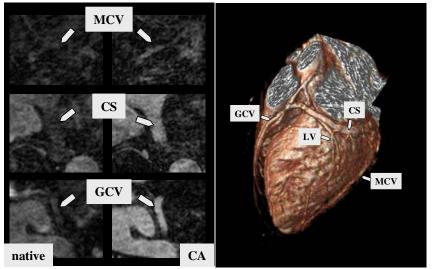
Comparison of native MRI and contrast-agent enhanced MRI (CA) for the mid cardiac vein (MCV), the coronary sinus (CS), and the great cardiac vein (GCV) (left); three-dimensional rendering of the coronary veins (right).
